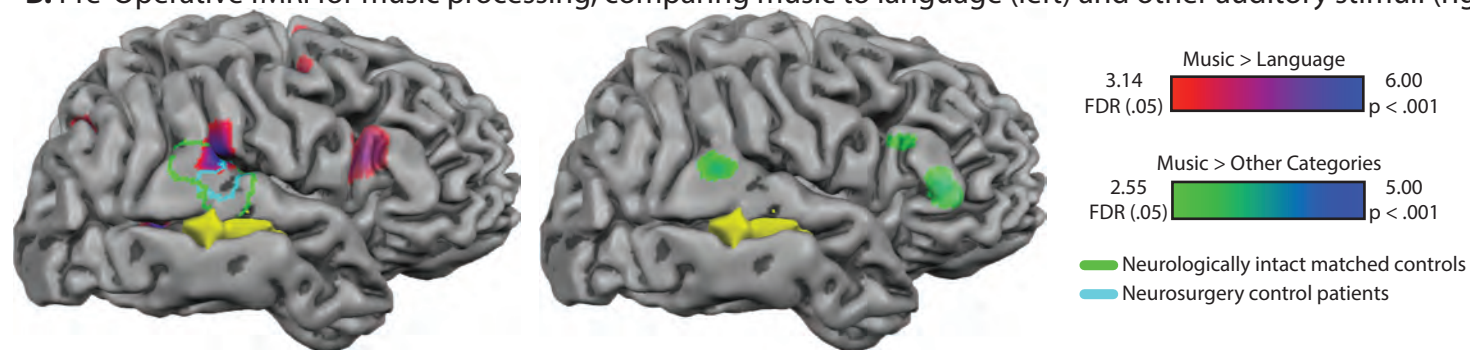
Pre-Operative functional and structural MRI and intraoperative direct electrical stimulation mapping in a professional musician with a glioma in the right posterior temporal lobe
